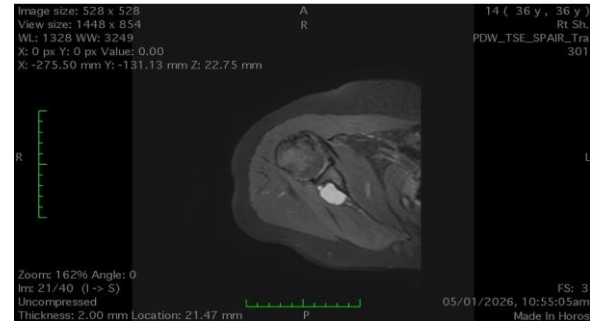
An MRI image of a female patient (case number 2) suggesting presence of spinoglenoid notch ganglionic cyst.
